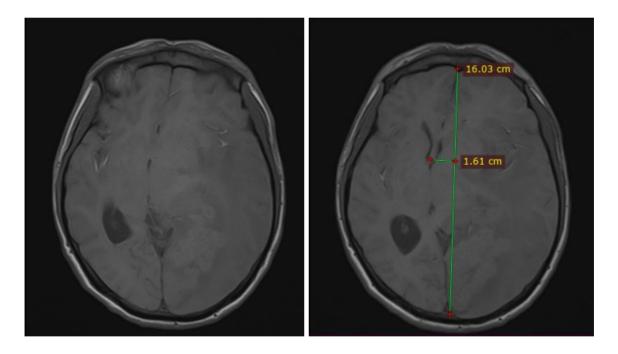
shows the cranial MRI T1WI showing isointense lesion at the left occipital area with surrounding iso to hypointensity which may represent perilesional edema. Midline shift of 1.5cm is also noted.
